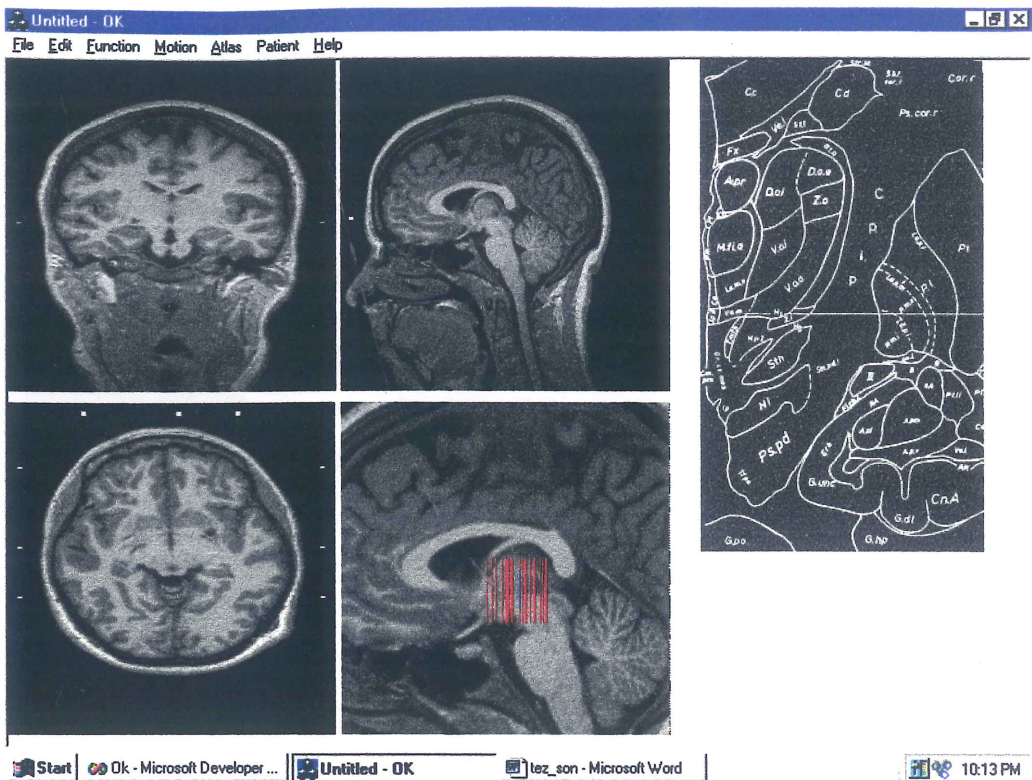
The case with zooming factor of 2 with red lines showing the places of frontal atlas overlays placed on sagittal CT image.
